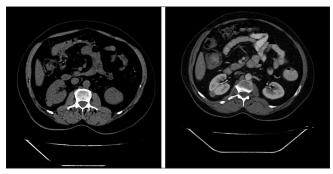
Computed tomography of abdomen showing a focal lesion in medial pole of the right kidney measuring 1.7 cm × 1.6 cm with contrast enhancement
